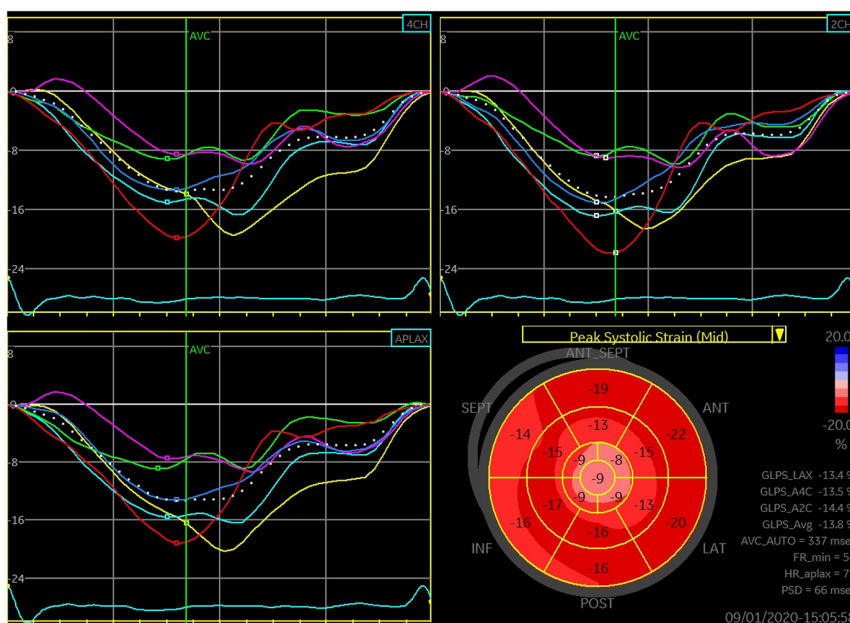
Global longitudinal strain before adrenalectomy. The green and purple curves represent apical segments. GLPS, global longitudinal peak strain; 4CH, apical four chamber view, 2CH, apical two chamber view; APLAX, apical long-axis view; MID, mid-wall; AVC, aortic valve closure; ANT-SEPT, anterior-septal; ANT, anterior; LAT, lateral; POST, posterior; INF, inferior; SEPT, septal; HR, heart rate.
